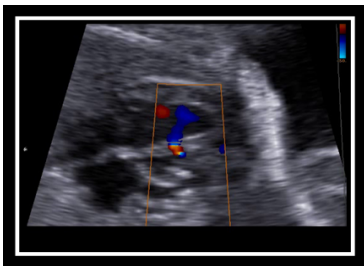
Ebstein anomaly. A 26 yrs old woman with 29 wks. of gestation was referred for routine antenatal check-up. The ultrasonography scans at the level of thorax shows a massive dilatation of right atrium. Tricuspid valve is displaced apically in right ventricle. Color Doppler showed tricuspid regurgitation. The pulmonary outflow shows pulmonary atresia. Left atrium and ventricle appears normal and outflow and inflow tracts shows normal Doppler parameters..
